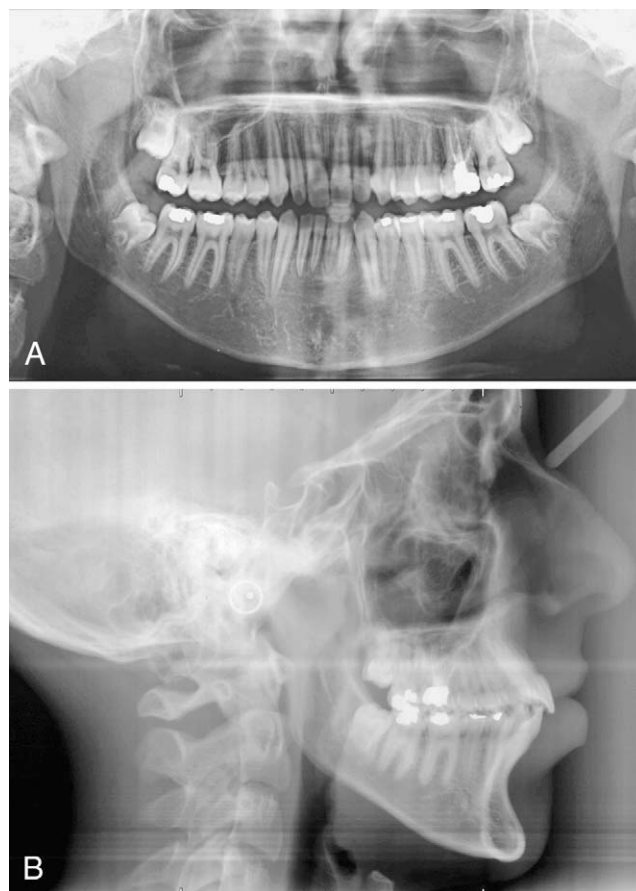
Posttreatment panoramic and cephalometric radiographs.
